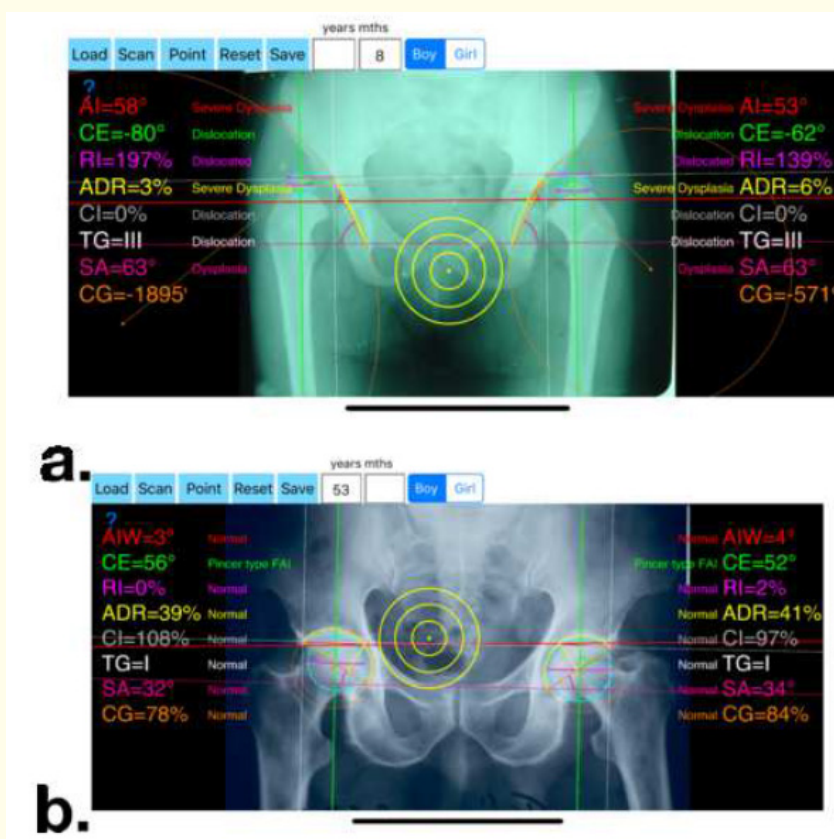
Radiographic Indexes calculated with the HipDysplasiaApp. a. At 32 months of age. b. At older age.
